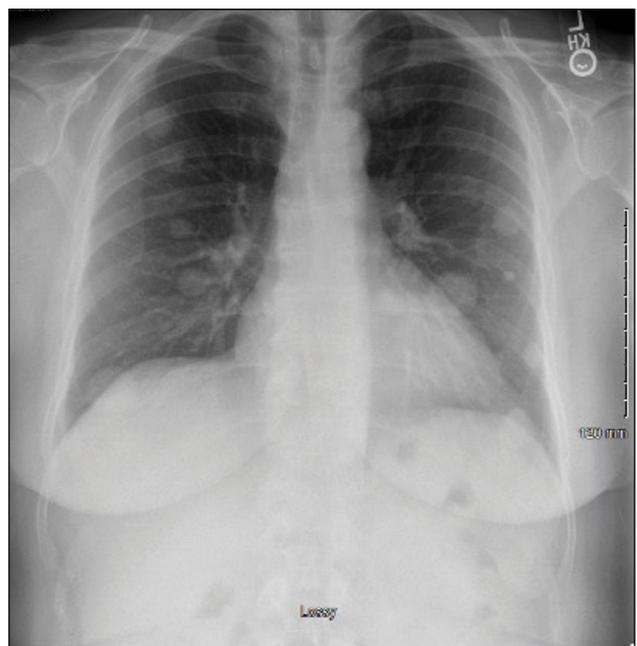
Chest X-ray showing multiple lung nodules bilaterally.
